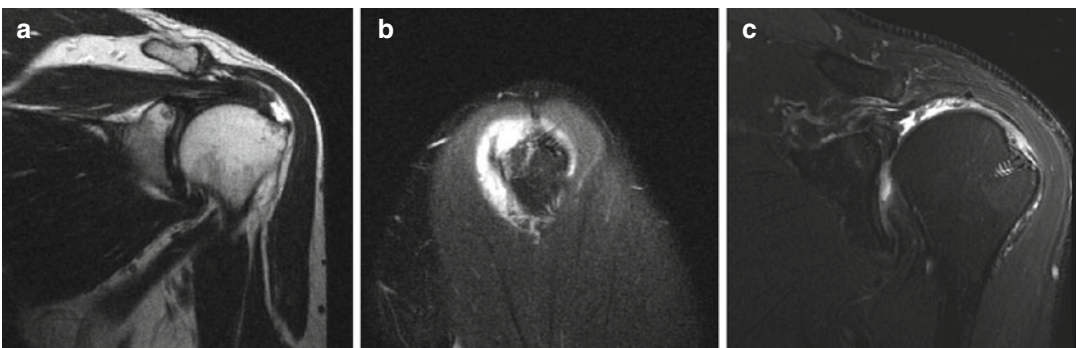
Coronal (left, a) and sagittal (center, b) MRI slices from a 64-year-old male showing a full-thickness rotator cuff tear. He underwent a single-anchor single-row rotator cuff repair at an outside institution for that injury
